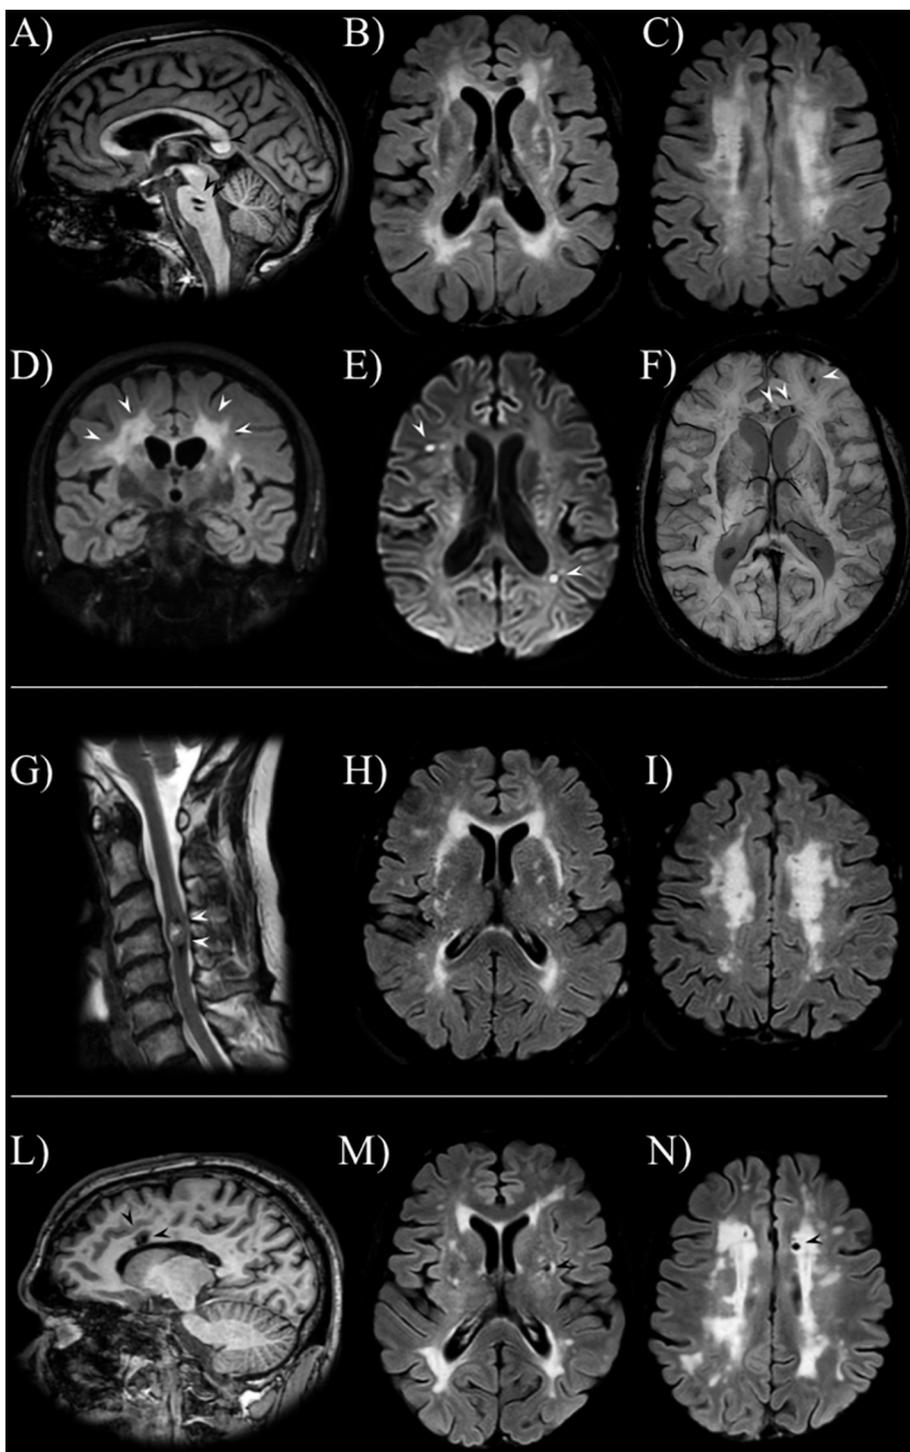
MRI of the proband (A-F), his mother (G-I) and his brother (L-N).
